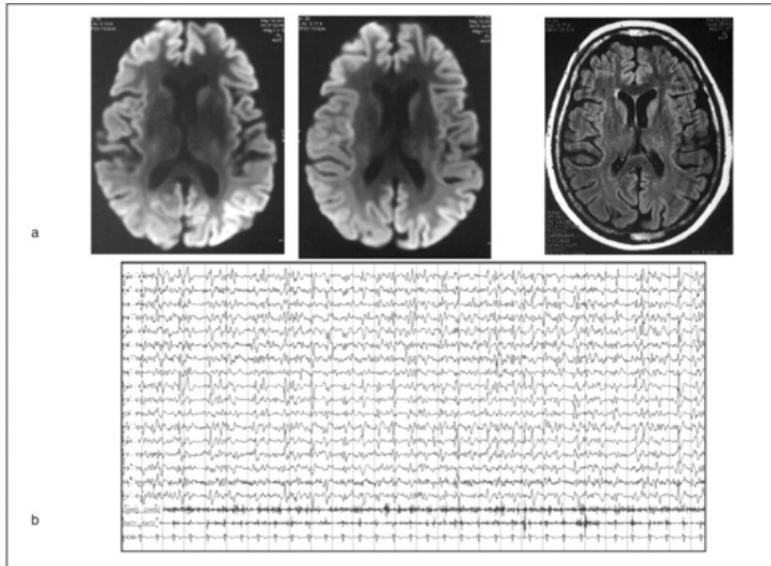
a) Two weeks later, axial MRI FLAIR and diffusion sequences showing a hyperintensity of the caudate nucleus bilaterally. b) EEG showing the appearance of periodic sharp slow-waves bilaterally.
